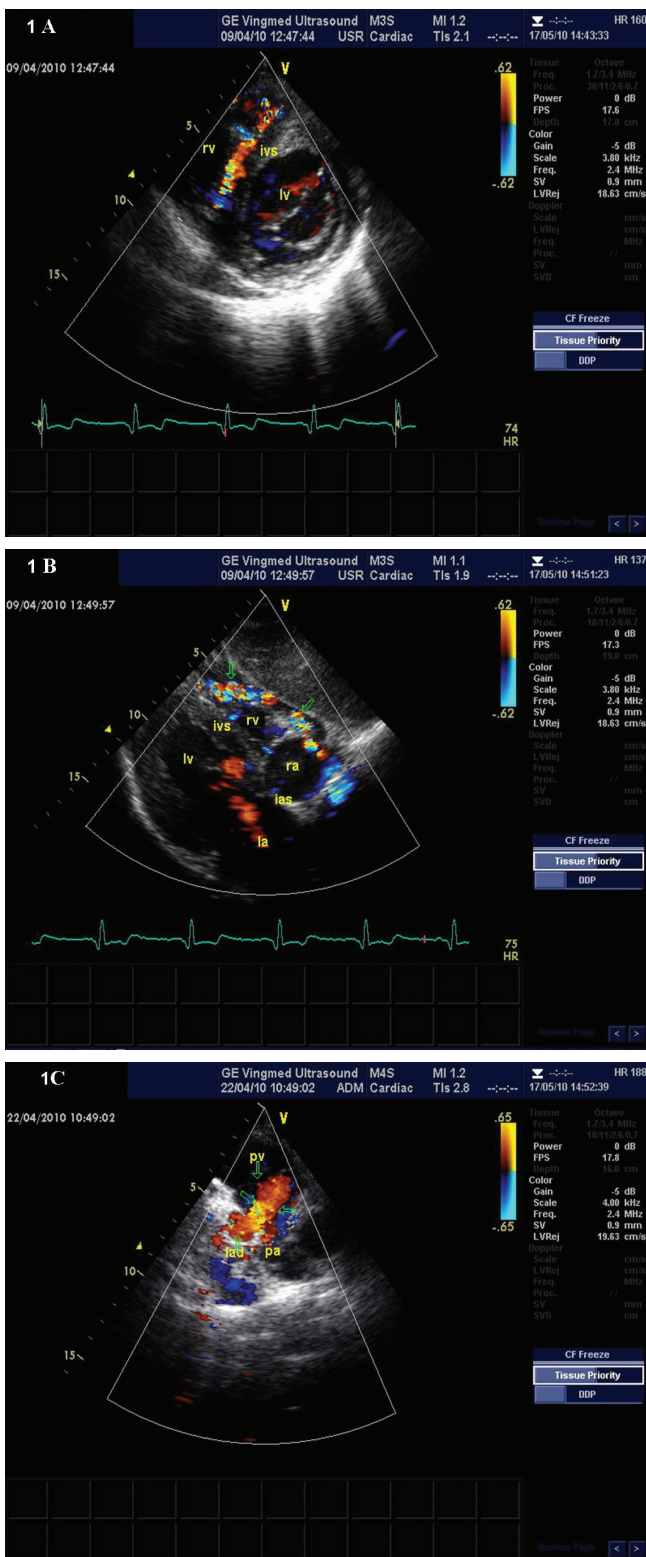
In TTE with colour Doppler, the parasternal short-axis view shows abnormal blood flow through the interventricular septum (A); the subcostal view shows abnormal blood flow patterns through the free wall of the right ventricle (B); the modified parasternal short-axis view shows retrograde flow from the LAD into the pulmonary artery and LAD orifice (C). Lv: left ventricle, rv: right ventricle, la: left atrium, ra: right atrium, ivs: interventricular septum, ias: interatrial septum. pv: pulmonary valve, pa: pulmonary artery, lad: left anterior descending artery.
